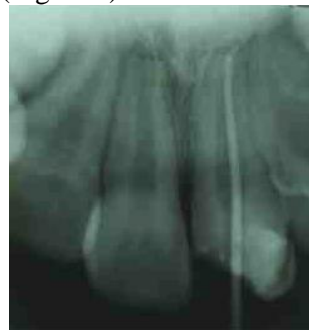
Preoperative IOPA X-ray
